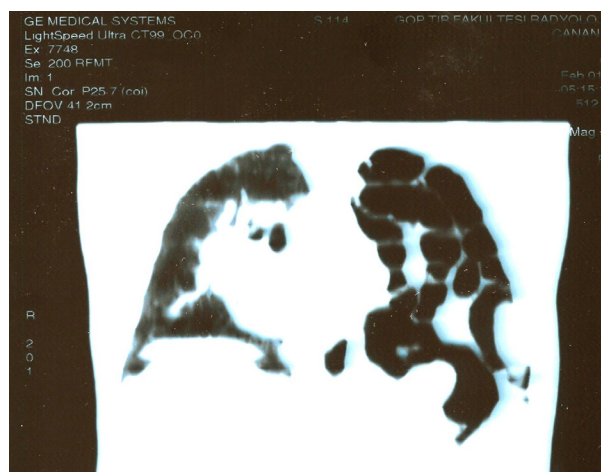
Barium enema orientated computed tomography of the patient.
